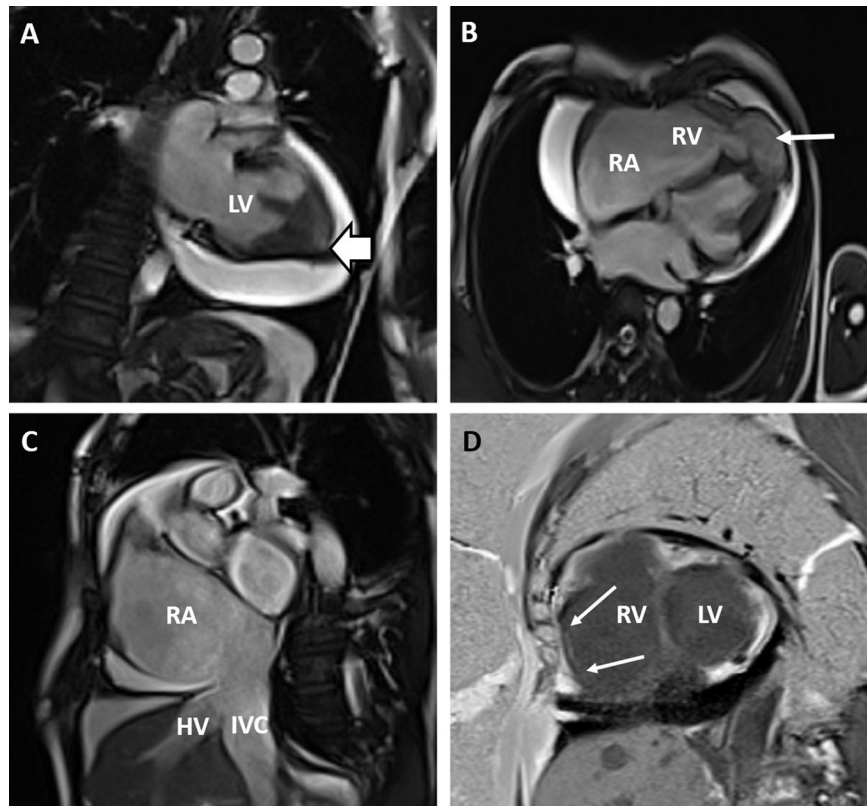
(A) CMR imaging, gradient echo sequence (white-blood pool phase) 2-chamber view, 2 min after 0.2-mmol/kg Gd-DTPA infusion demonstrates left ventricular apical obliteration (arrow). Note the apical filling of the left ventricle exhibiting a lower signal than adjacent myocardium. Significant pericardial effusion is noted. (B) Same sequence, four chamber view demonstrates small right ventricle with prominent apical aneurysm (asterisk). (C) Same sequence, short axis view showing dilated right atrium, hepatic vein and inferior venacava. (D) Delayed enhanced sequence in short axis 10 min after Gd-DTPA infusion. Right ventricular subendocardium showing high signal suggesting fibrosis (arrows). HV – hepatic vein, IVC – inferior venacava, CMR imaging – cardiac magnetic resonance imaging, Gd-DTPA – gadolinium diethylene triamine penta acetic acid.
